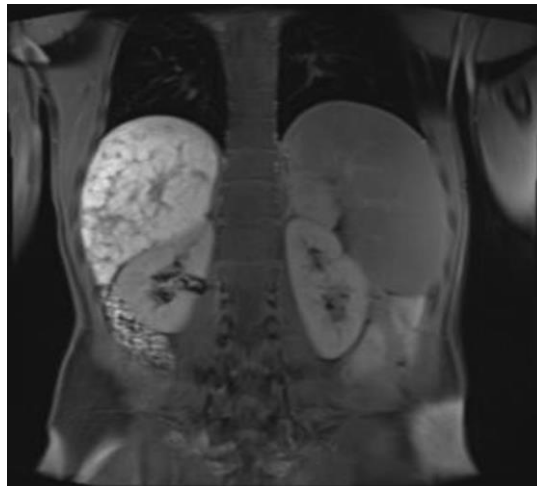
Patchy, usually linedated clumping contrast enhancing areas of right liver lobe at venous phases, Axial and coronal Contrast enhanced MR images.
